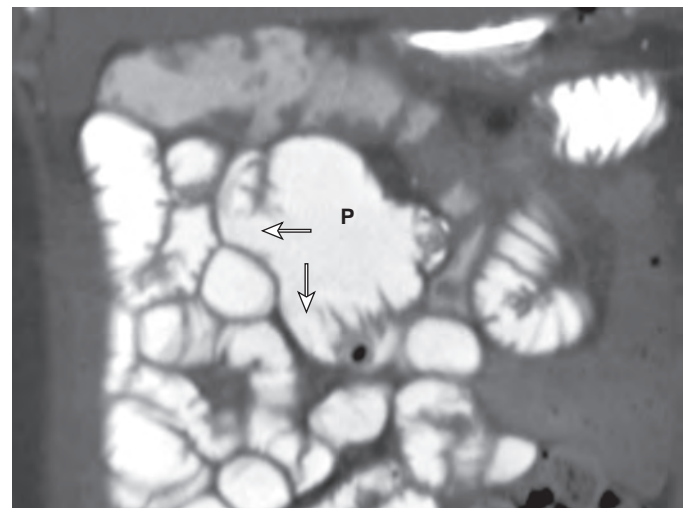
Blind pouch. CT enteroclysis shows formation of a sacular blind pouch (P) associated with a prior side-to-side jejunal anastomosis. Arrows point to the afferent and efferent limbs.
